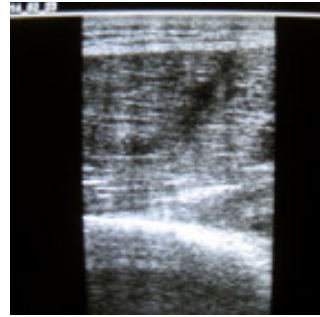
a,b. Acute tenosynovitis of the extensor tendon of the wrist showing hypoechoic thickening of the tendon sheath. On color Doppler there is significant increase in the vascularity.
